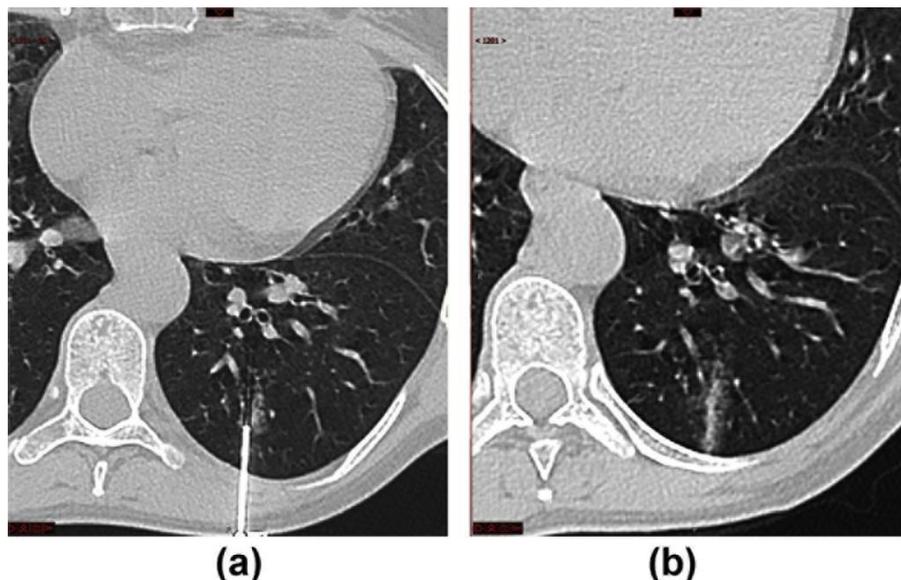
(a) A 63-year-old female patient with a 2 cm ground-glass nodule in the left lower lobe. During PTLB, she was placed in the prone position. The lesion was approached from the posterior chest wall. An axial unenhanced CT image (lung window) acquired during the biopsy shows the 17 G coaxial needle positioned adjacent to the lesion in the left lower lobe.
